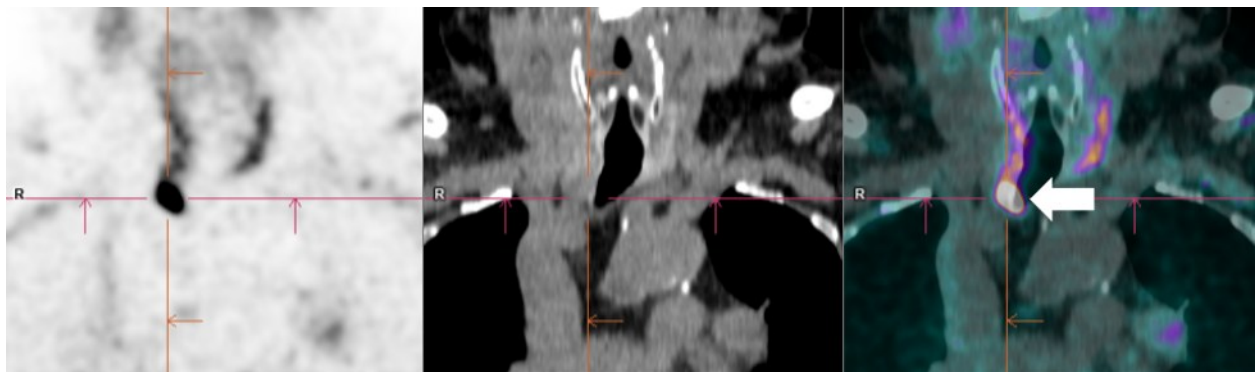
Coronal PET/CT images showed an FCH-avid (SUV of 16.6) focus in the inferior pole of the right thyroid lobe at the level of the sternoclavicular joint, between the proximal right common carotid artery and trachea at the level of the sternoclavicular joint (white arrow), measuring 1.5 x 0.9 x 0.6 cm. This is suggestive of a parathyroid adenoma.
